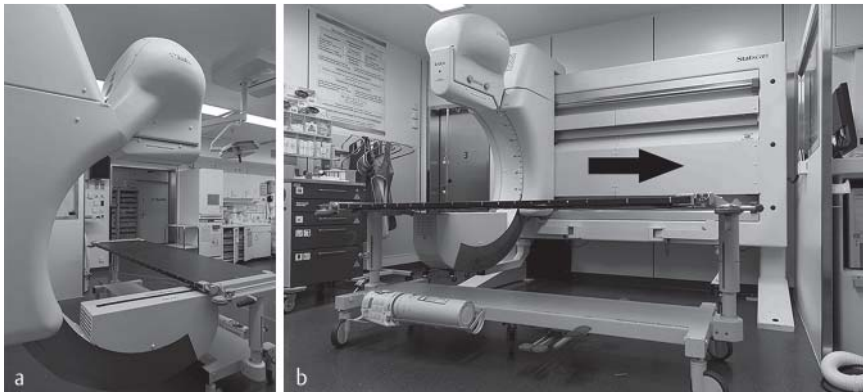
Lodox Statscan in the emergency department. a shows the C-arm with the rotating anode X-ray tube above and the X-ray detector unit under the table. b shows the carbon fiber table of LS with the Statscan operator console on the right side. The arrow indicates the scanning direction of the C-arm.
